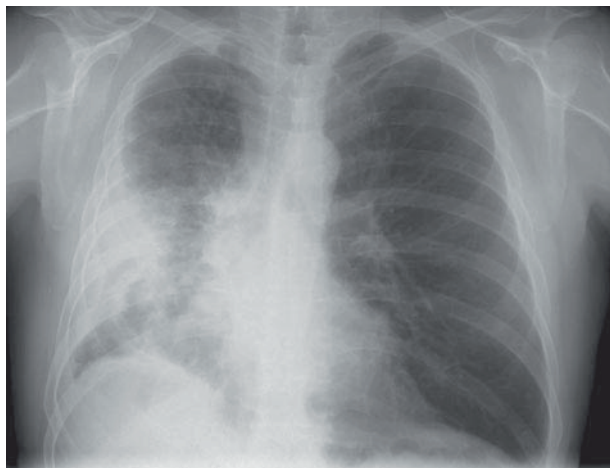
Chest radiograph demonstrating consolidative changes in the right middle and lower lobes, with a wedge-like distribution in the lateral aspect of the right lung field.
